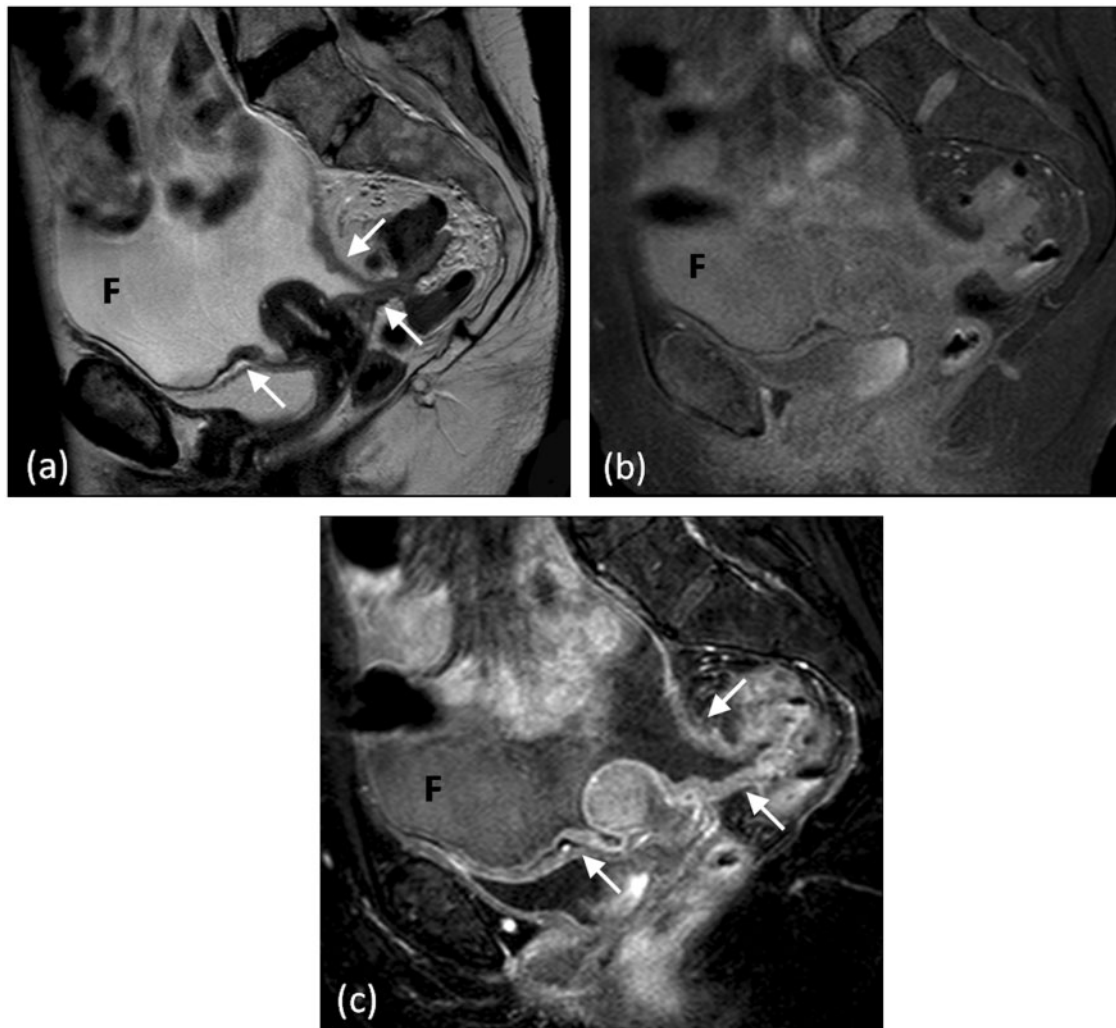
Pelvic peritoneal involvement. (a) Sagittal T2-weighted MRI depicting peritoneal thickening and nodularity (arrows). Sagittal T1-weighted fat-saturated MRI (b) before and (c) after intravenous injection of gadolinium demonstrating marked abnormal peritoneal enhancement. Ascitic fluid (F) outlines the pelvic peritoneal spaces.
